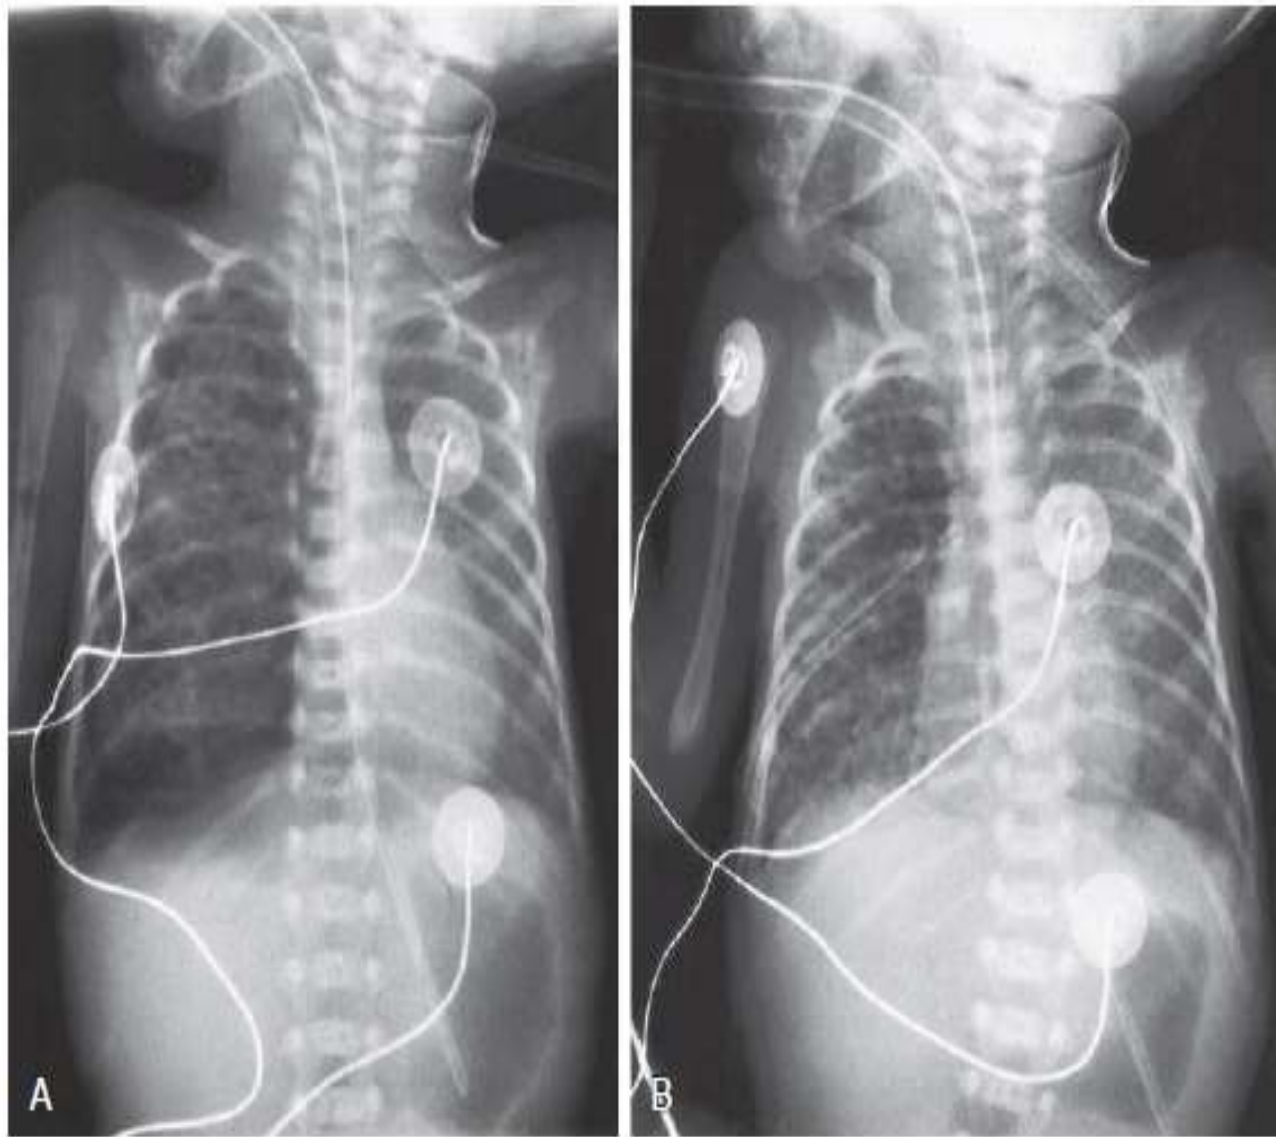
A, Right-sided tension pneumothorax and widespread right lung pulmonary interstitial emphysema in a preterm infant receiving intensive care. B, Resolution of pneumothorax with a chest tube in place. Pulmonary interstitial emphysema (PIE) persists. (From Meerstadt PWD, Gyll C: Manual of neonatal emergency x-ray interpretation, Philadelphia, 1994, WB Saunders, p. 73.)
